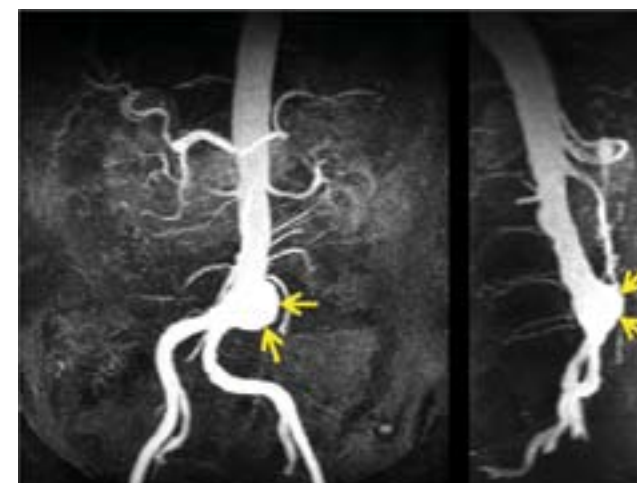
MR image of the abdominal vessels acquired at 1.5T using an 8-channel abdominal phased array coil demonstrating an aneurysm in the aorta (arrows) seen in a 3D coronal image (left) and in a reformatted sagittal image (right).
